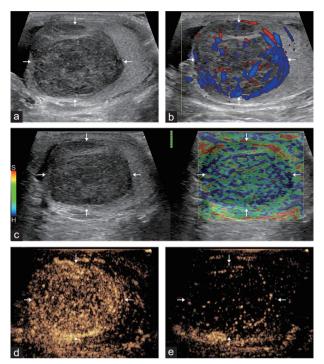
A 38-year-old male with a right testicular seminoma. (a) Grayscale US image shows a 38-mm, regular, margin circumscribed, and hypoechoic lesion (arrowheads) in the right testis. (b) Color Doppler US image shows mixed (peripheral and central) vascularization. (c) Strain elastography image shows a medium-to-hard (encoded blue-green) focal lesion. CEUS image shows (d) homogeneous hyperenhancement during the early phase and (e) isoenhancement during the late phase relative to the adjacent parenchyma. The arrows indicate testicular lesion seminoma. US: ultrasound; CEUS: contrast-enhanced US; S: soft; H: hard.
